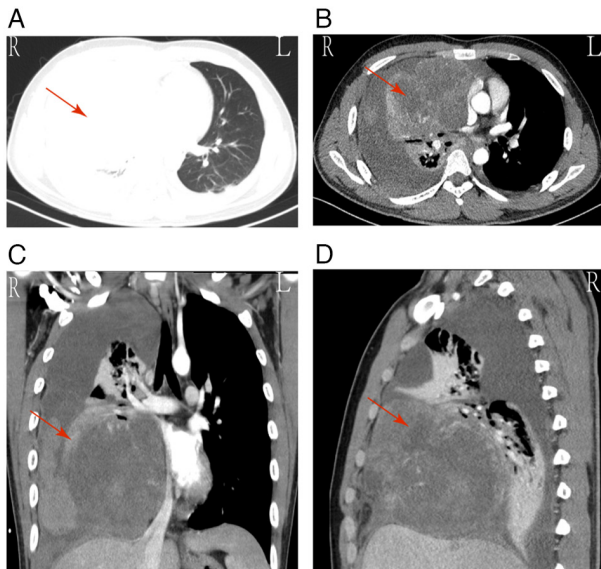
Results of chest CT examination. (A) Axial, (B) sagittal and (C and D) coronal scans of the CT scan of the chest. The red arrow indicates the location of the tumor. According to the results, the tumor was considered to be malignant and might have invaded the pericardium, pleura and right atrium. R, right; L, left; CT, computed tomography.
